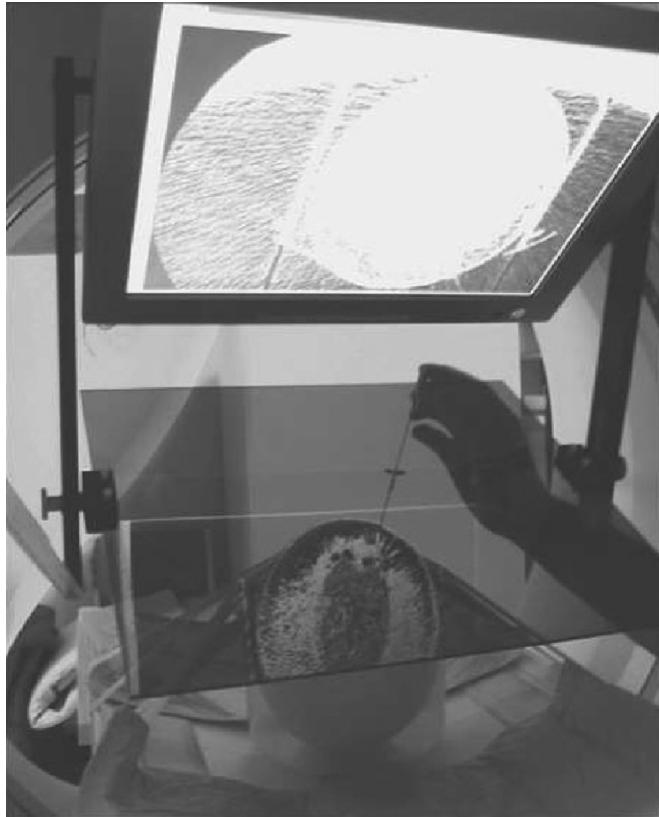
CT reflection [79]: Concept and prototypical setup. © 2005 IEEE.
